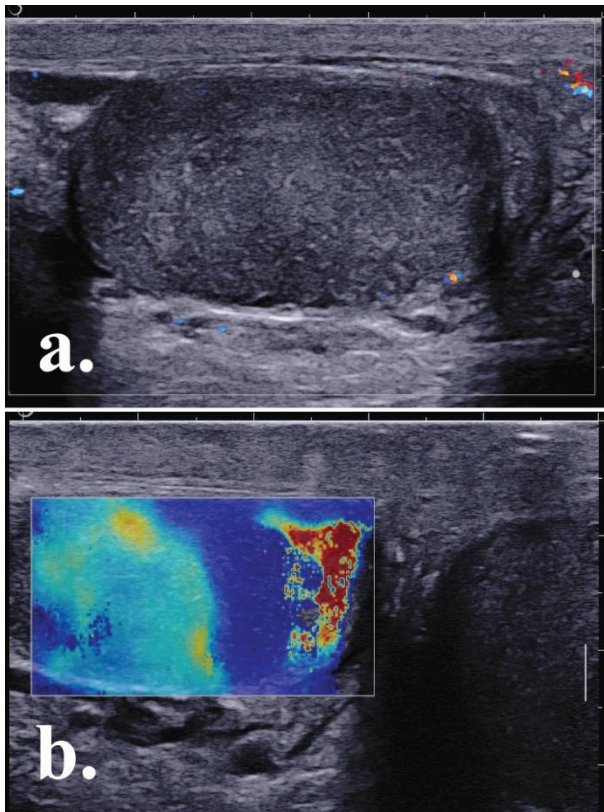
a) color Doppler examination: hypoechoic testicle, discretely inhomogeneous, without focal mass, without vascular signal; b) 2DSWE - high stiffness of the upper half of the twisted testicle. Pathology – testicular torsion and embryonal cell carcinoma in the upper half of the testicle.
